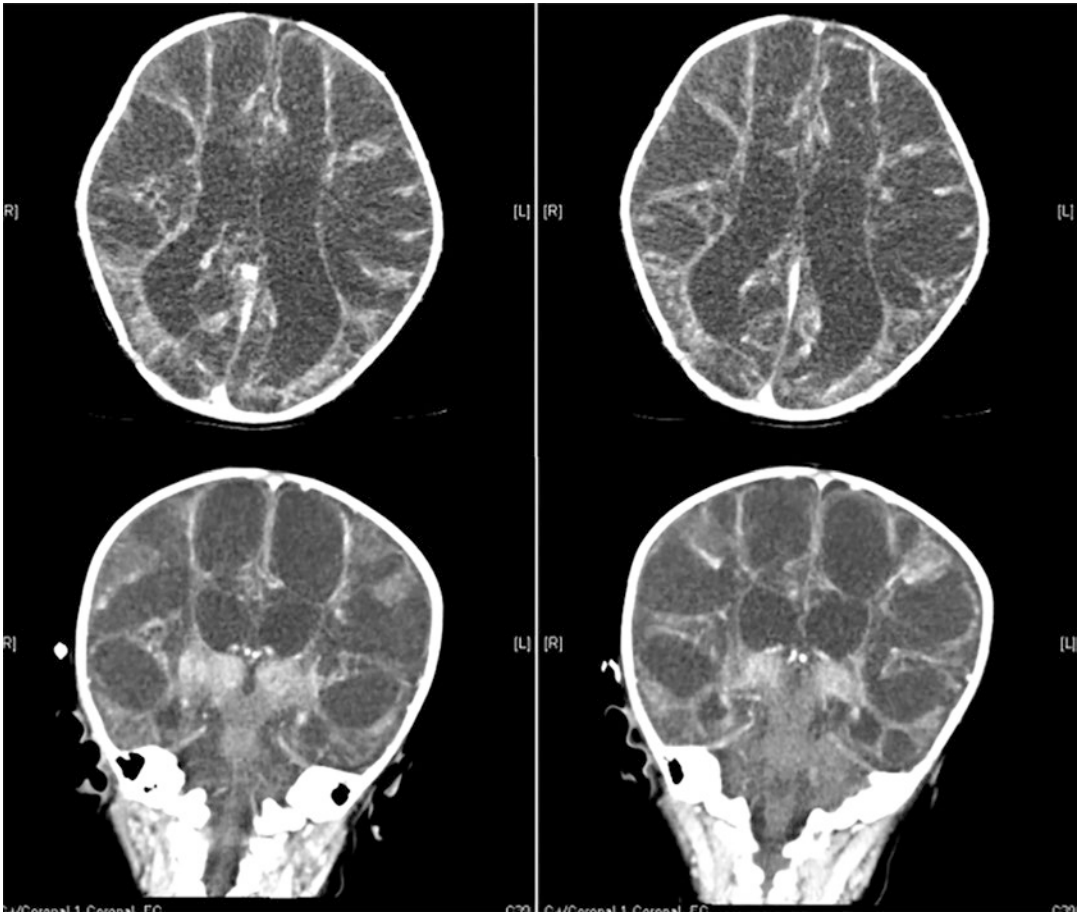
Follow-up brain computed tomography 3 weeks after antiviral treatment showed diffuse encephalomalacia in axial plane (upper two films) and coronal plane (lower two films)
